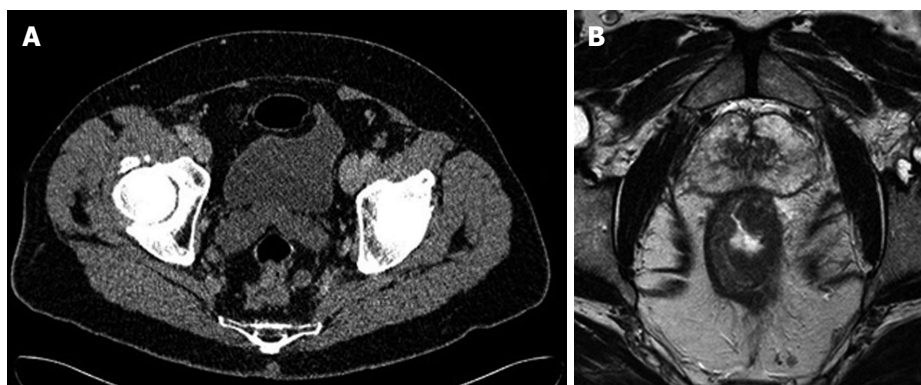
Computed tomography (A) and magnetic resonance imaging (B) of the T3 rectal cancer. Note poor quality of circumferential margin on the computed tomography scan compared to the magnetic resonance imaging.
